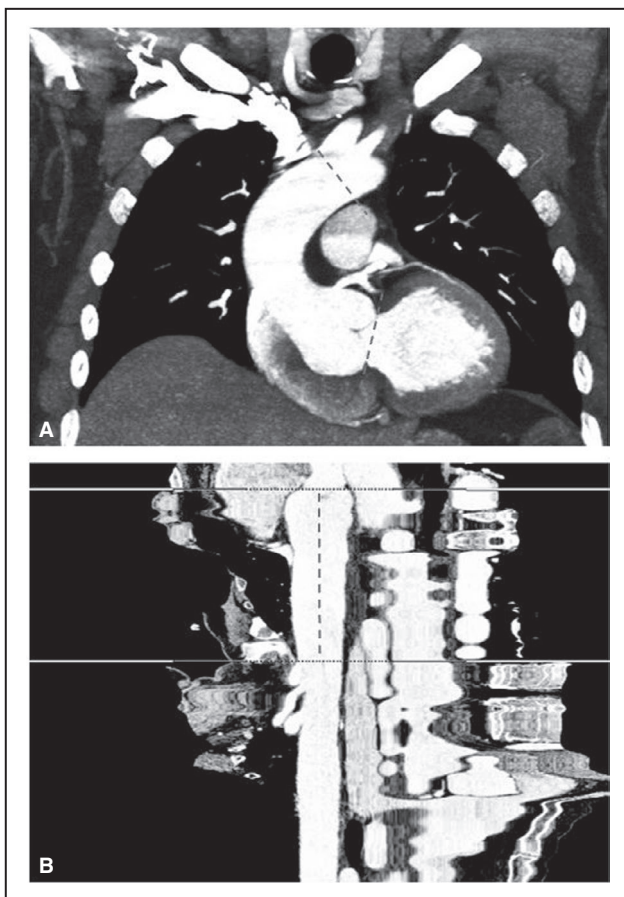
Measuring ascending aortic length by computed tomography.
